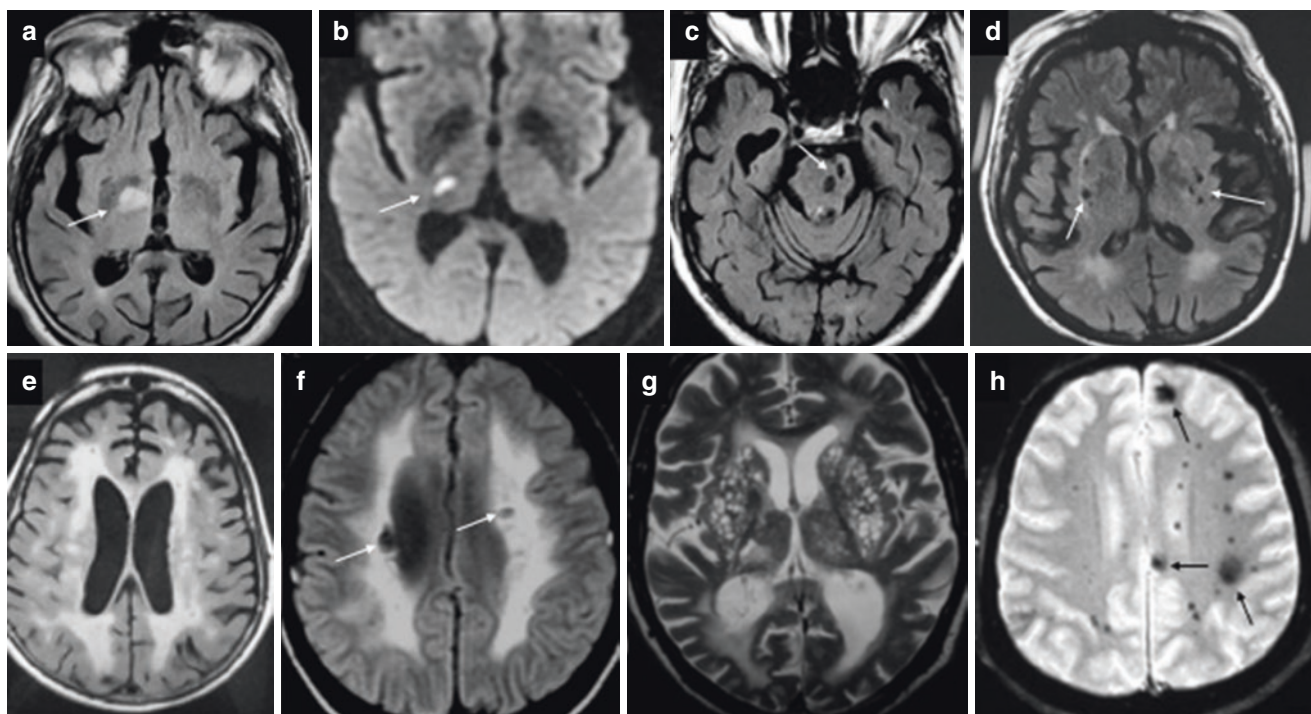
MRI imaging characteristics of features of cerebral small vessel disease commonly seen in patients with diabetes. (a) FLAIR sequence depicts a thalamic lacunar infarct (arrow). (b) Diffusion-weighted shows a hyperintense lesion corresponding to an acute small deep (lacunar) infarct (arrow): less than 2 cm diameter. (c) T1-weighted imaging with a hypointense lesions in the pons corresponding to old lacunar infarcts (arrow). (d) FLAIR sequence showing multiple small deep lacunar infarcts (arrows). (e) FLAIR imaging of typical large confluent areas of white matter hyperintensities (WMH) extending from
